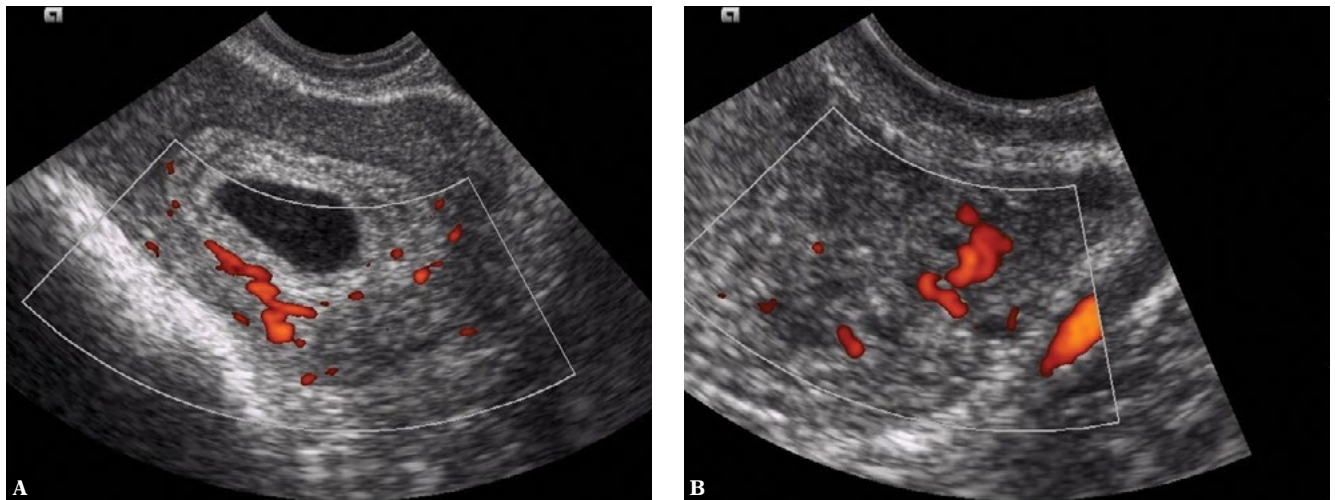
Power Doppler images showing the spiral arteries in A. threatened abortion at 5 weeks; B. normal case at 4 weeks 5 days
